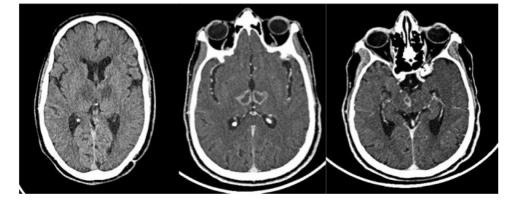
CT scan without and after injection of the PDC was carried out which objectified the presence of 2 hypodense lesions in spontaneous contrast at the level thalamic bilaterally and right midbrain enhanced in an annular fashion after injection of PDC, surrounded by a collar of perilesional edema.
